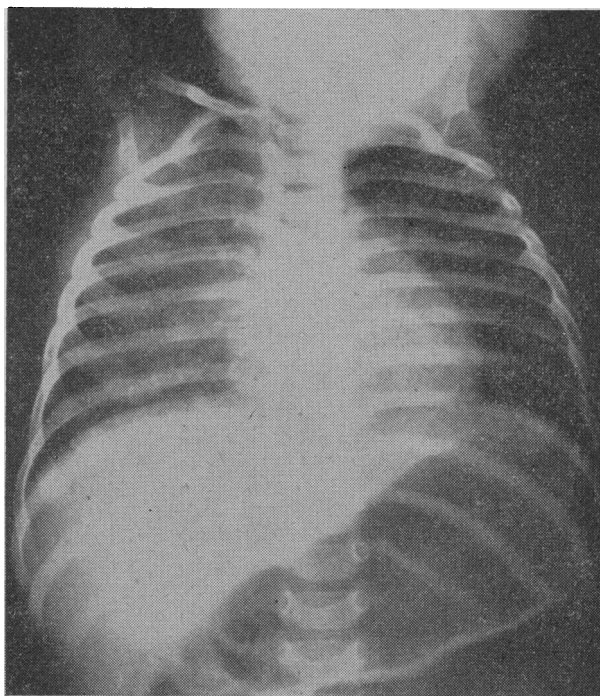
Radiograph taken on November 16 showing shadowing to be more confluent.
